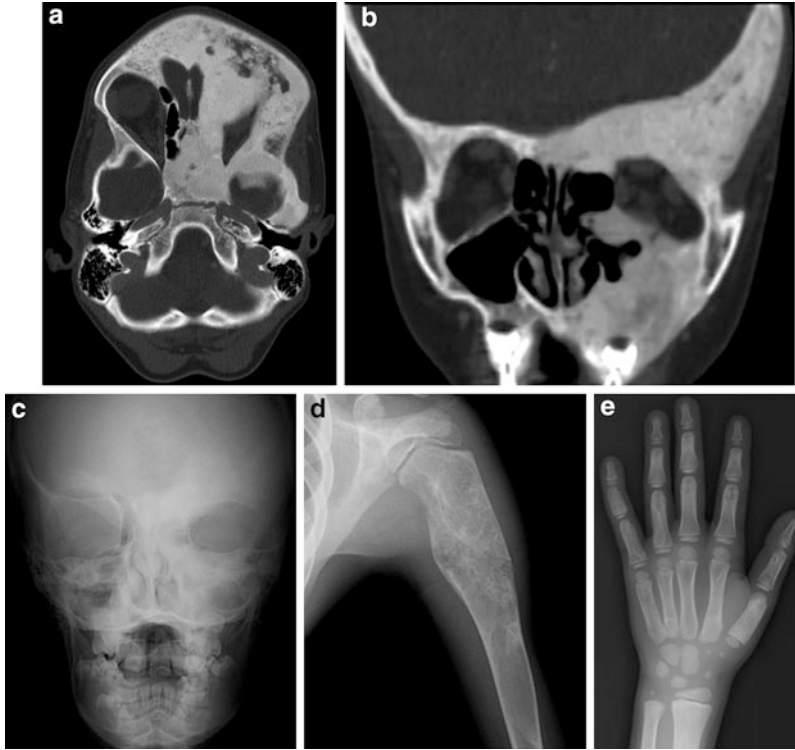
(a-e) A boy has a diagnosis of McCune–Albright syndrome with polyostotic fibrous dysplasia and multiple cafe au lait spots with jagged borders and freckling. At age 6, head CT images (a, b) showed diffuse ground glass density, expansile bone lesion present in the high left parietal and left frontotemporal region. It involved the entire left the sphenoid bone, maxillary bone, superior bilateral nasal bones. It also extended into the anterior aspect of bilateral ethmoid sinuses as well as bilateral sphenoid sinuses. Posterior portion of the left orbital
